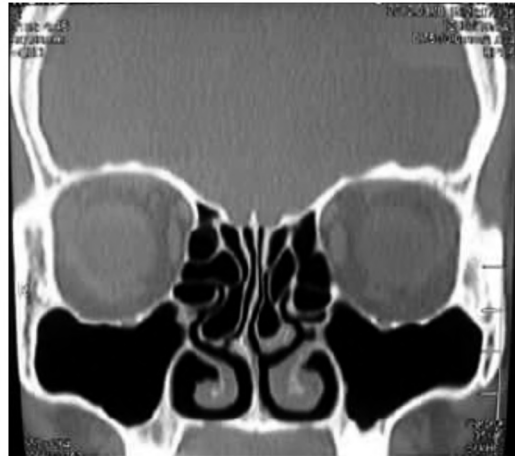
Coronal CT scan showing deviated septum to right, pneumatized middle turbinate (right concha bullosa) with small left concha bullosa.
